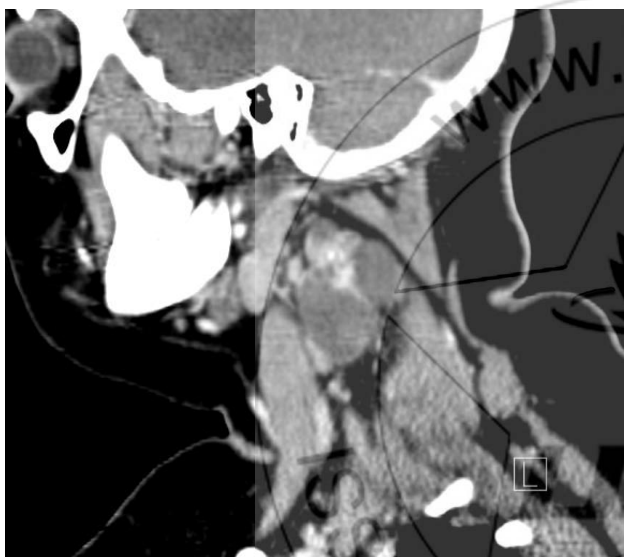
Sagittal CT scan of the neck with contrast showed cystic mass with multiple reactive lymph nodes
